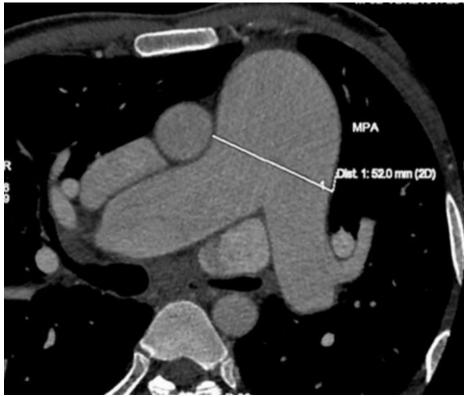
Axial chest CT at the level of pulmonary artery trunkbifurcation The right pulmonary artery (RPA) and left pulmonary artery (LPA) are dilated. Main pulmonary artery (MPA) is severely dilated and measures 52 mm.
